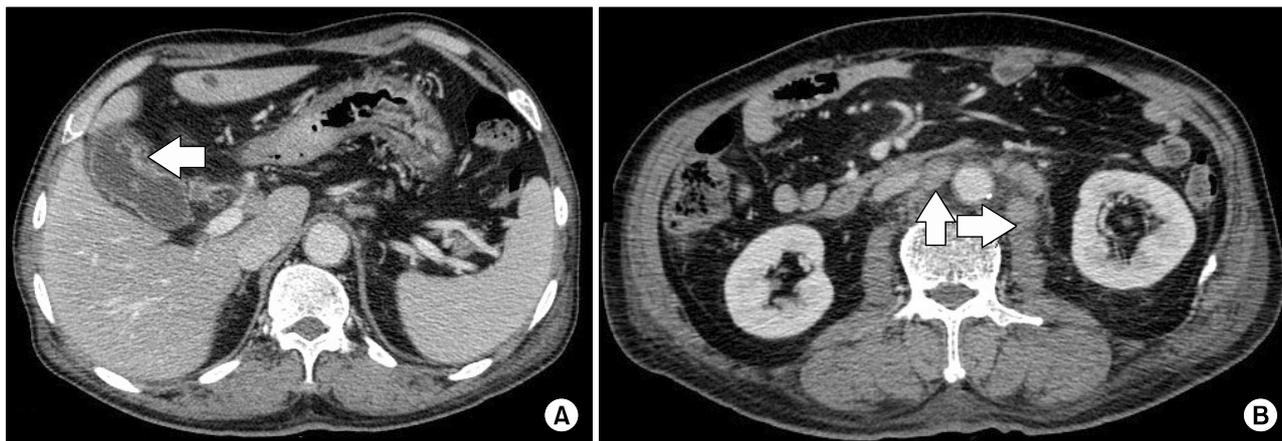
Biliary dynamic CT scan. (A) Irregular wall thickening of the gallbladder with pericholecystic fat infiltration and GB cancer with serosa invasion (T3). (B) Enlarged lymph nodes were seen at the cystic duct, portahepatis, portocaval, and bilateral para-aortic space, which are suggestive of metastatic lymph nodes.
